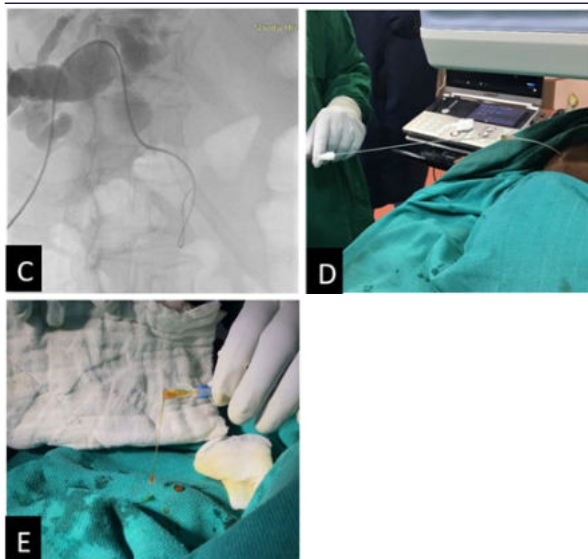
A. Ultrasound B. Fluoroscopic images showing dilated biliary radicles in patient with Hilar Cholangiocarcinoma, C& D. Right sided Internal and Externalisation of Biliary catheter done. E. Free flow of bile
